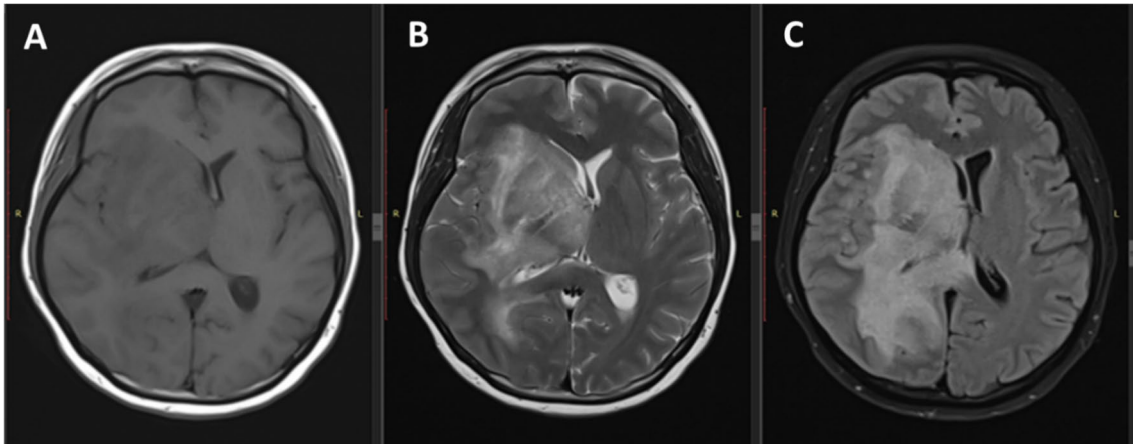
Axial A T1W, B T2W and C FLAIR sequence of MRI brain images. The MRI findings demonstrate hypointense signal intensity of white matter edema on T1W image. Meanwhile, it demonstrates hyperintense of the edema on T2W and FLAIR images
